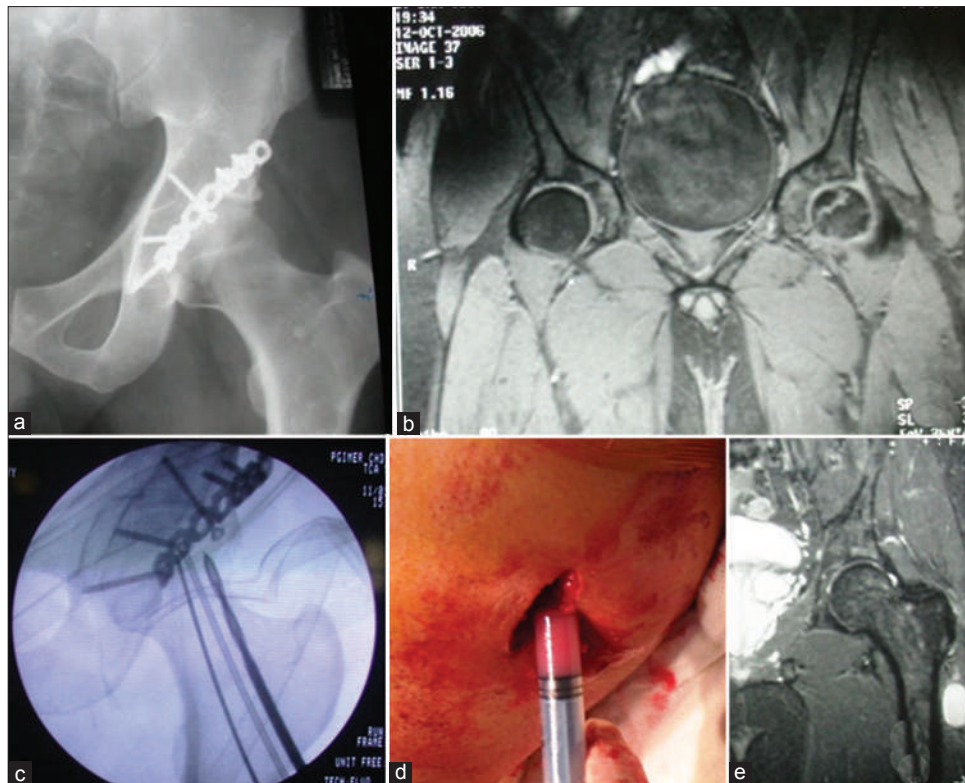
(a) Plain x-ray anteroposterior view of left hip in a 32-year old young patient showing posttraumatic AVN in its early stage (b) MRI of both hips showing early avascular changes (c) Intraoperative photographs demonstrating core decompression and (d) bone marrow concentrate instillation inside the core tract. (e) After 15 months, the necrotic lesion has completely healed
